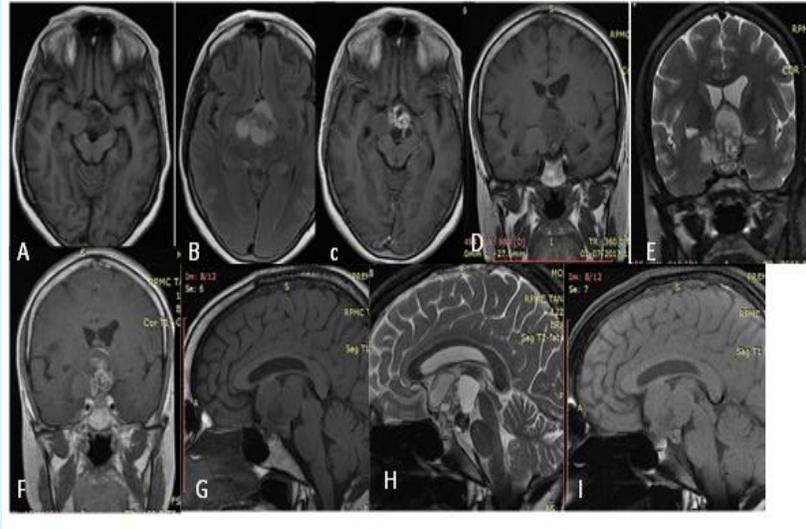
(A-I): A 12 year Female child presenting with headache, vomiting and visual disturbances MRI images shows a well-defined multiloculated multisystem supra-sellar mass with enhancement of solid component and wall on post gadolinium images. The Axial T1W, FLAIR, POST CONTRAST (A-C): Coronal T1W, T2W and POST CONTRAST (D-F): Saggital T1W, T2W and POST CONTRAST (G-I): and wall on post gadolinium images.
